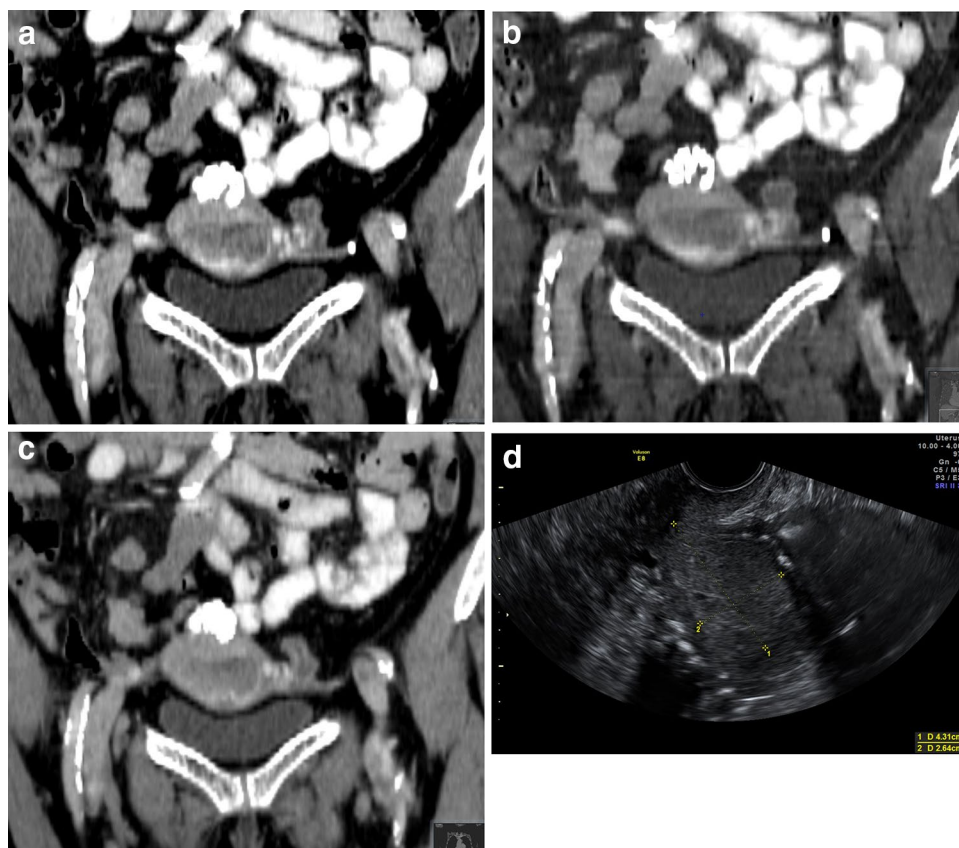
A 70-year-old patient with endometrial cancer stage Ib. The lesion's margins, which infiltrated the myometrium >50%, especially on the right side, are better visible in the CT coronal reconstruction at 50 keV (a), although these images show more artifacts, and iodine reconstructions (b), whereas it is less delineated on the 70 keV images (c). The same lesion was also seen and measured in US (d)
